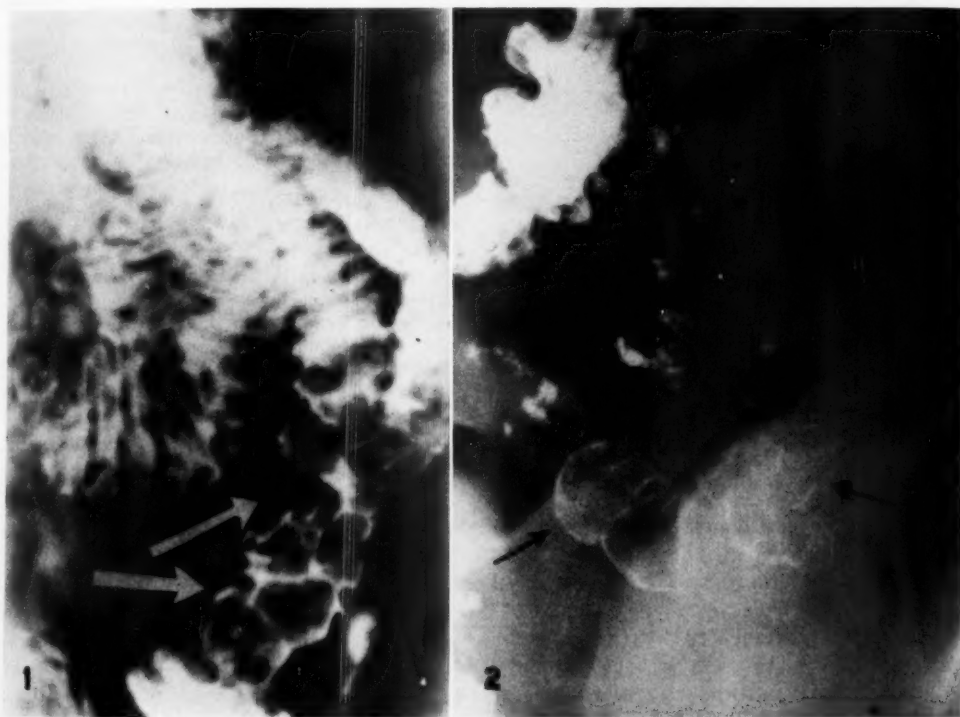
Spot roentgenogram of a jejunal loop showing multiple filling defects at site of hemangioma.
